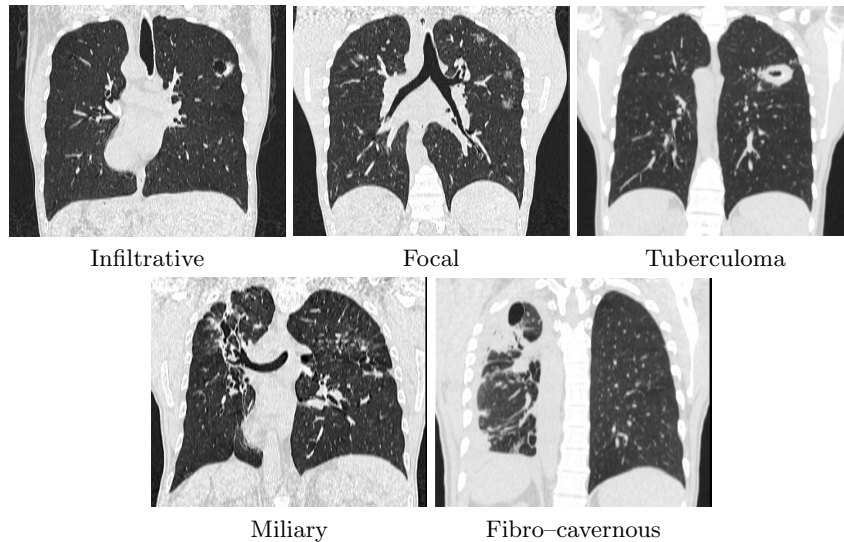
Examples of the five tuberculosis types in the TBT subtask. The CT slices are shown using a HU window with center at -500 HU and width of 1400 HU
